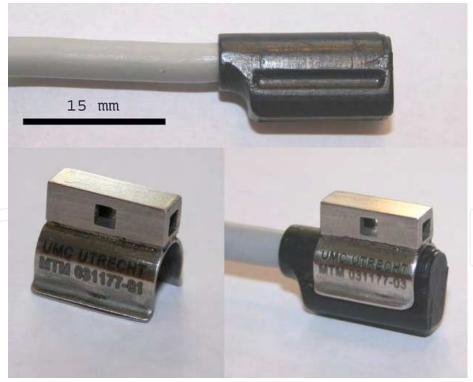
Thirteen MHz epicardial ultrasound mini-transducer (upper panel), custom made snap-on metal clip (left lower panel) and clip attached to mini-transducer (right lower panel). The clip is designed specifically for easy handling of the mini-transducer by the end-effectors of the robot instruments
